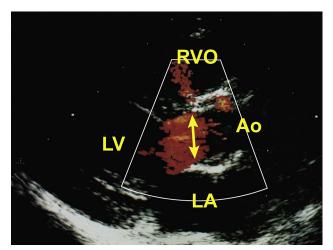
Long-axis echocardiographic image with color Doppler showing homogeneous red color in the LV outflow tract (double-sided arrow), suggesting that flow is laminar. Ao, Aorta; LA, left atrium; RVO, right ventricular outflow tract. Reproduced with permission from Gewillig et al.45
